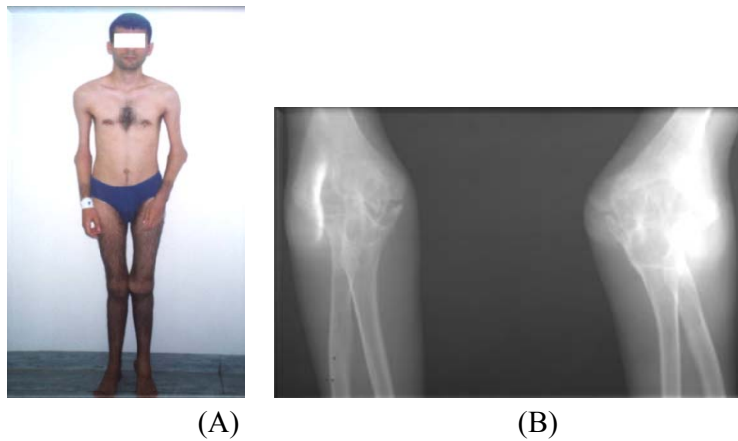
(A) Clinical aspect (B) preoperative X-ray, notice the widening and deformity of the epiphysis, disappearance of the normal joint space.
